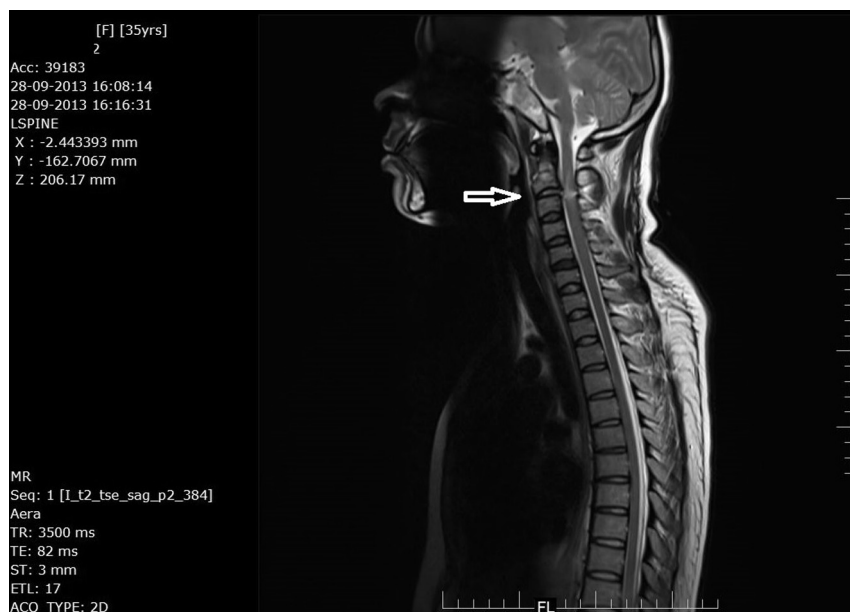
This T2W MRI of cervico-dorsal spine showing (arrow) cord injury at the level of C2–C3.
